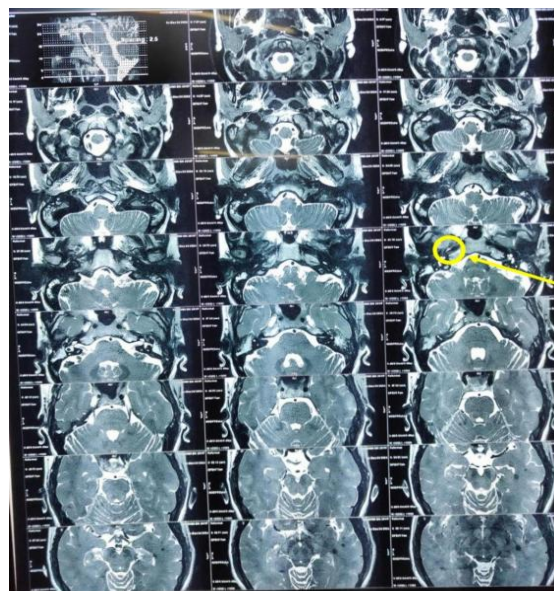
Coronal MRI scan highlighting anatomical structures and potential abnormalities.
